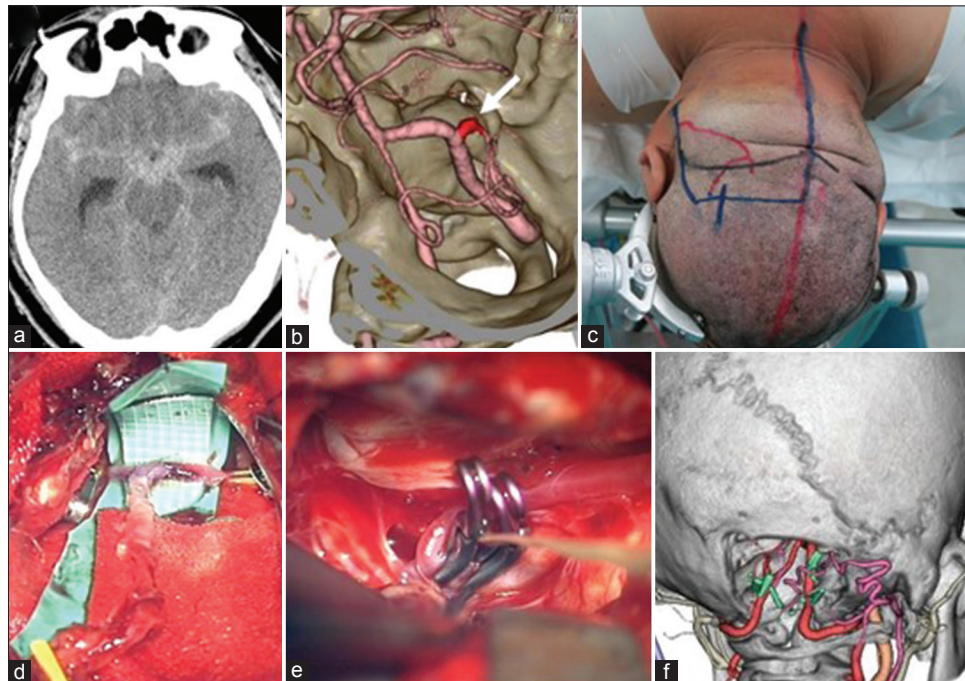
Case 10: (a and b: white arrow) Preoperative three-dimensional computed tomography angiography showing a ruptured distal posterior inferior cerebellar artery dissecting aneurysm on the right. (c-e) Emergent occipital artery-posterior inferior cerebellar artery bypass and trapping of the distal posterior inferior cerebellar artery dissecting lesion through the transcondylar fossa approach were performed. (f) Postoperative three-dimensional computed tomography angiography showing good bypass graft patency
